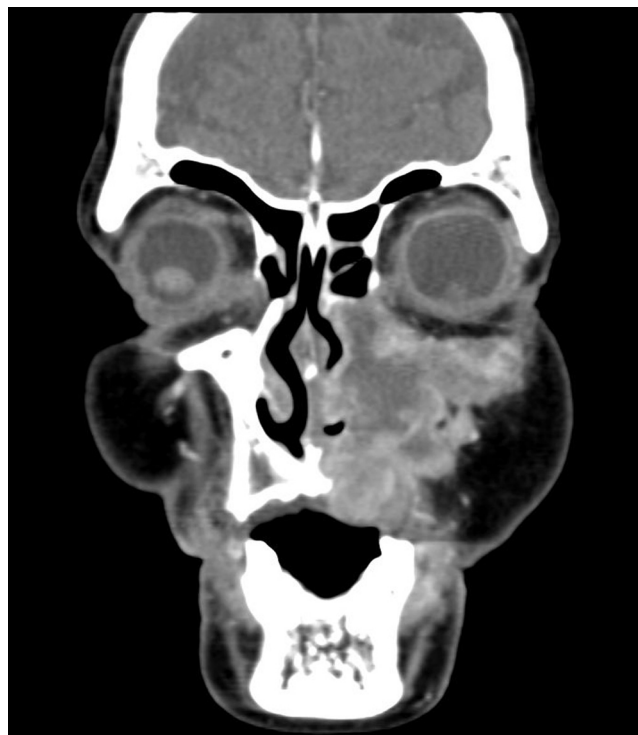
CT scan of the tumor in frontal plane of the cheek reg
